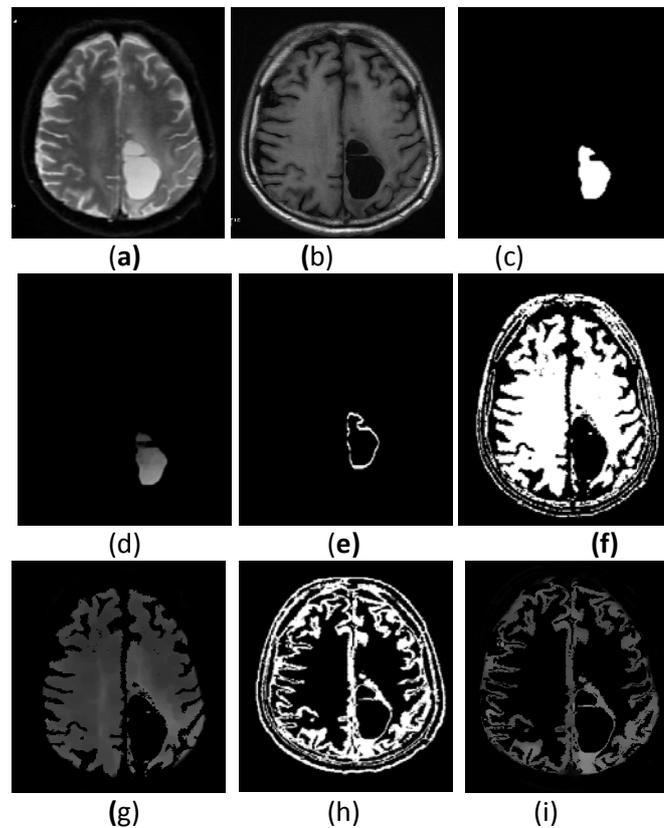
Example of segmented ROIs of low grade glioma tumor from MR image slices. a) T2 weighted b)T1 FLAIR MR image c) Segmented binary low grade glioma tumor d) Gray level tumor e) extracted tumor boundary. f)Binary segmented WM with tumor portion removed g) Gray level WM with outer layers removed h) Segmented binary GM i) Gray level GM with outer layers removed.
